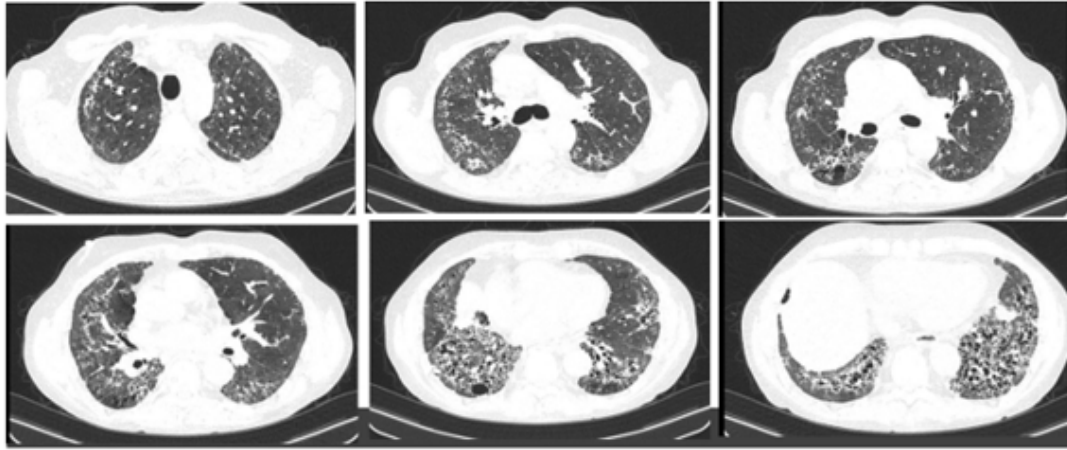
Axial HRCT images from 2023. showing further progression.
